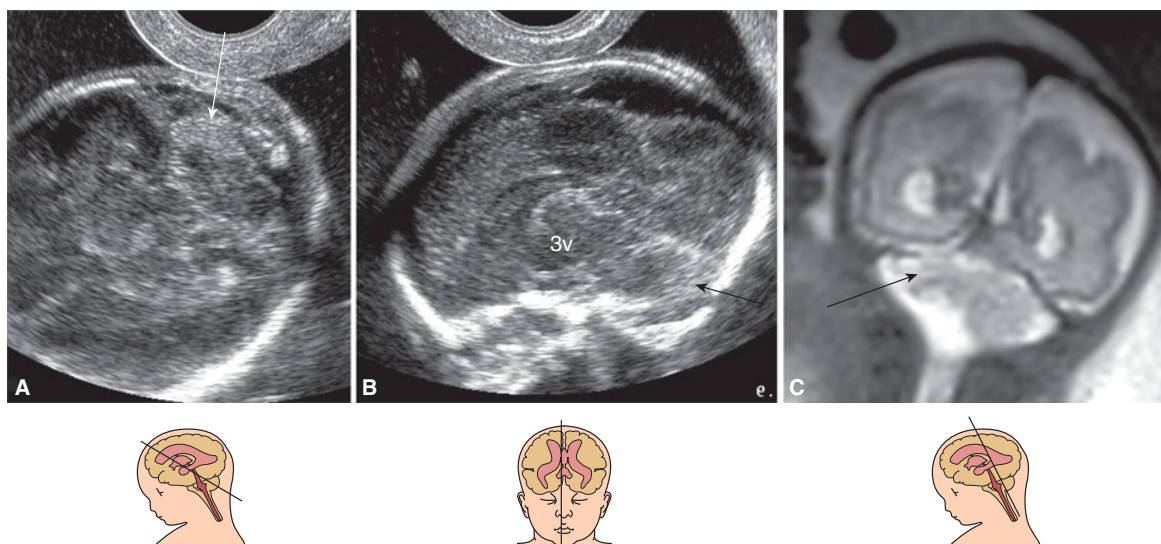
Acquired intrauterine lesion of one cerebellar hemisphere. This fetus developed severe anemia and hydrops as a consequence of anti-D alloimmunization. It was resuscitated with intrauterine transfusions but developed an intense echogenicity of one cerebellar hemisphere that eventually became atrophic. The vermis and contralateral hemisphere appeared intact. The neurologic and intellectual development was normal at long-term postnatal follow-up. (Reproduced, with permission, from Ghi T, Brondelli L, Simonazzi G, Valeri B, Santini D, Sandri F, Ancora G, Pili G. Sonographic demonstration of brain injury in fetuses with severe red blood cell alloimmunization undergoing intrauterine transfusions. *Ultrasound Obstet Gynecol.* 2004;23(5):428–431.)⁵⁷
